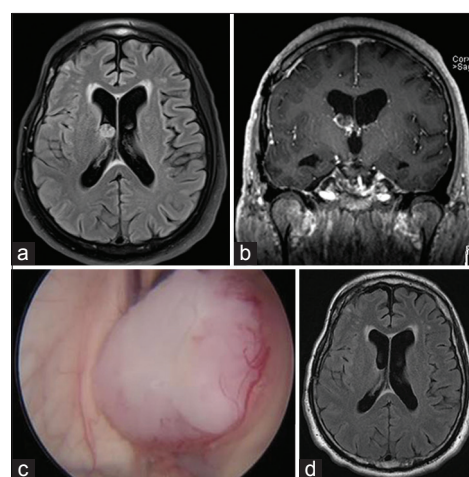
(a and b) Preoperative magnetic resonance imaging demonstrates an enhancing lesion, approximately 1.5 cm × 1.0 cm, along the ependymal surface within the right lateral ventricle caudothalamic notch. (c) Intraoperative view of intraventricular lesion via endoscope prior to resection. (d) Postoperative magnetic resonance imaging demonstrates gross total resection
